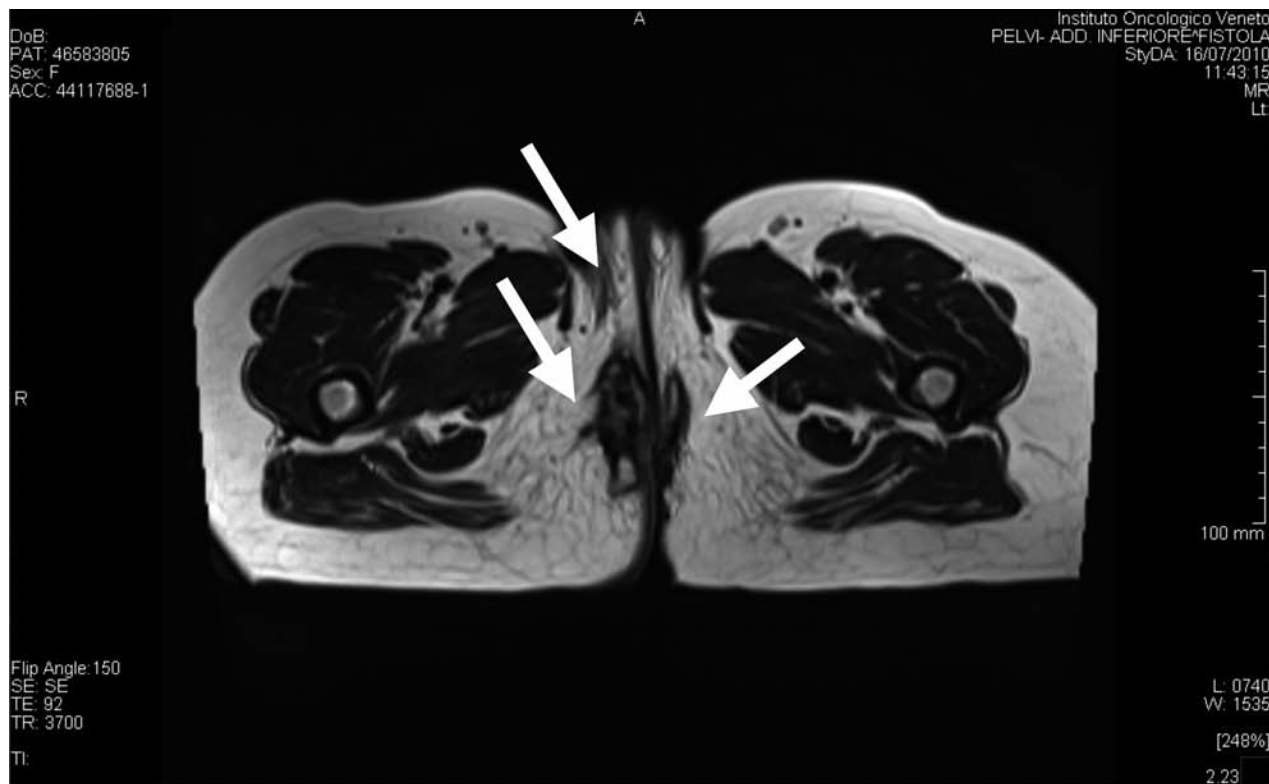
MR image of the perineal floor showing the complex fistulous picture of our patient (Arrows)
